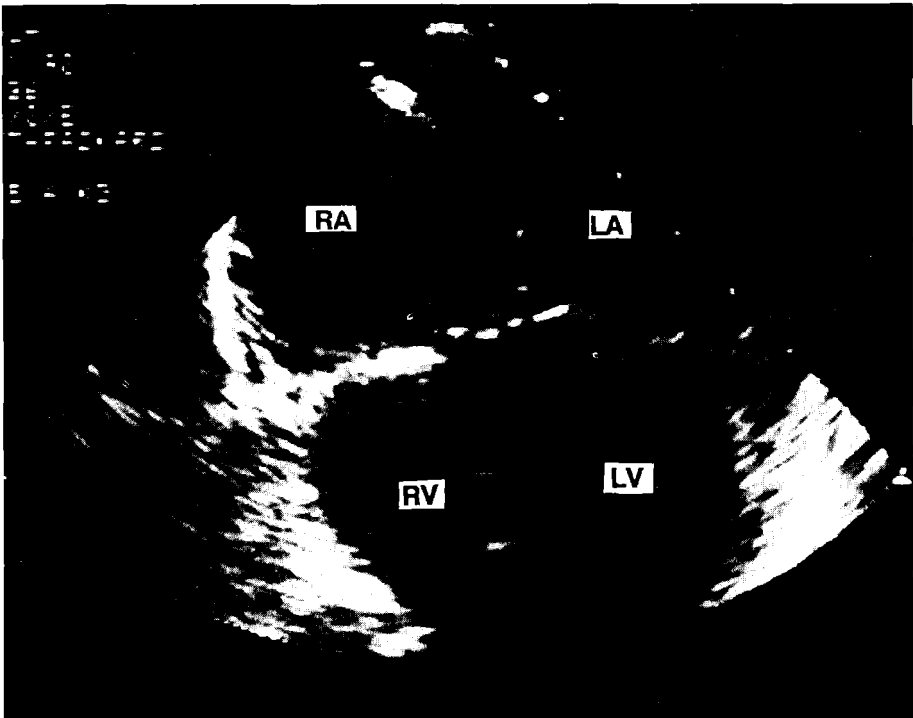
Transoesophageal four chamber view in a patient with atrial situs solitus, left juxtaposition of the atrial appendages, concordant atrioventricular connections and discordant ventriculo-arterial connections. The posterior portion of the atrial septum is typically deviated to a more frontal plane in this standard view. Note the hypoplastic tricuspid valve and the right ventricular cavity. The interatrial septum is intact on this view.
